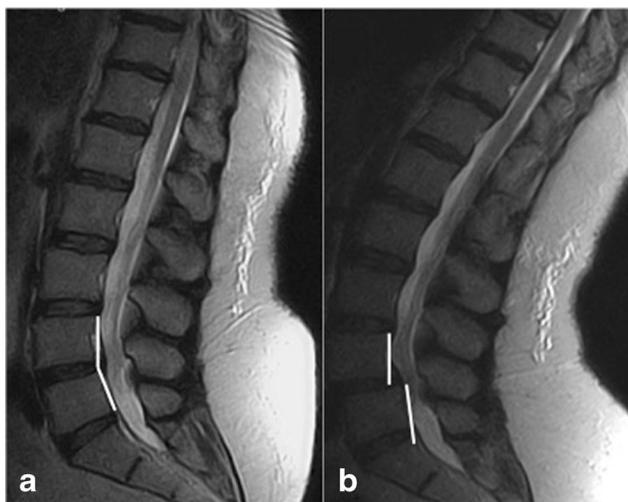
Sagittal T2-weighted TSE in supine (a) and upright (b) standing. Anterolisthesis of L4-L5 is evident in b (white lines)
